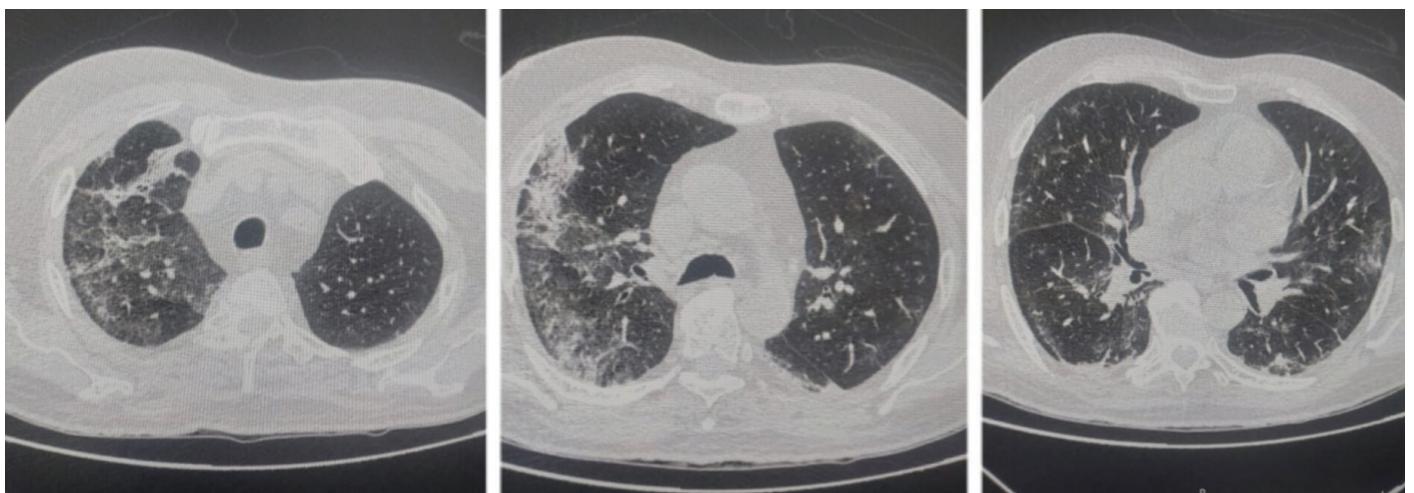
HRCT chest showing ground glass opacities irregular densities and reticular opacities with tractional bronchiectasis concerning fibrosis in bilateral lung fields to be correlated for sequelae to prior viral panel
